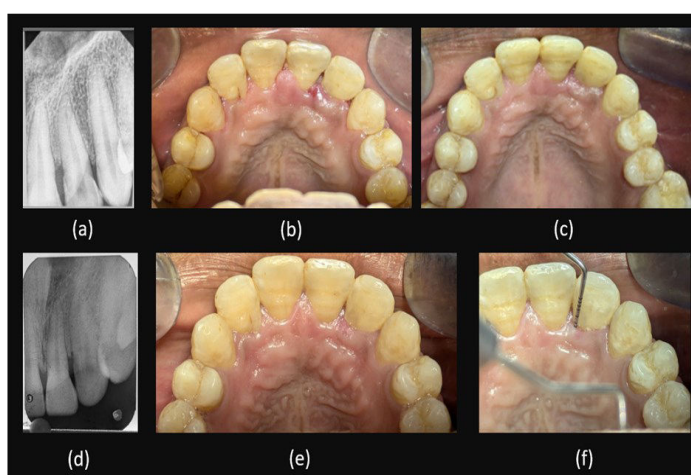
a) Post operative radiograph, b) Suture removal after 1 week of the surgery, c) Follow-up photograph after 3 months, d) Follow-up radiograph after 1 year, e) Follow-up photograph after 1 year, f) Normal pocket probing depth after 1 year
